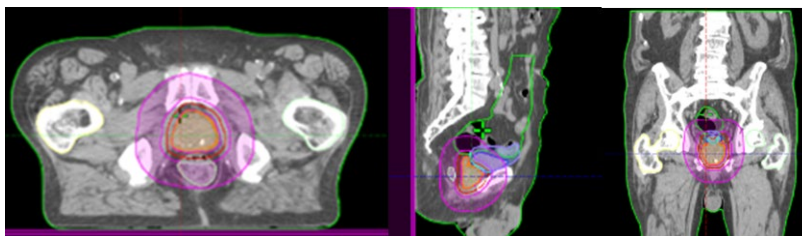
Computed tomography that outlines targeted volumes and normal organs and structures in the preparation of external beam radiotherapy.
